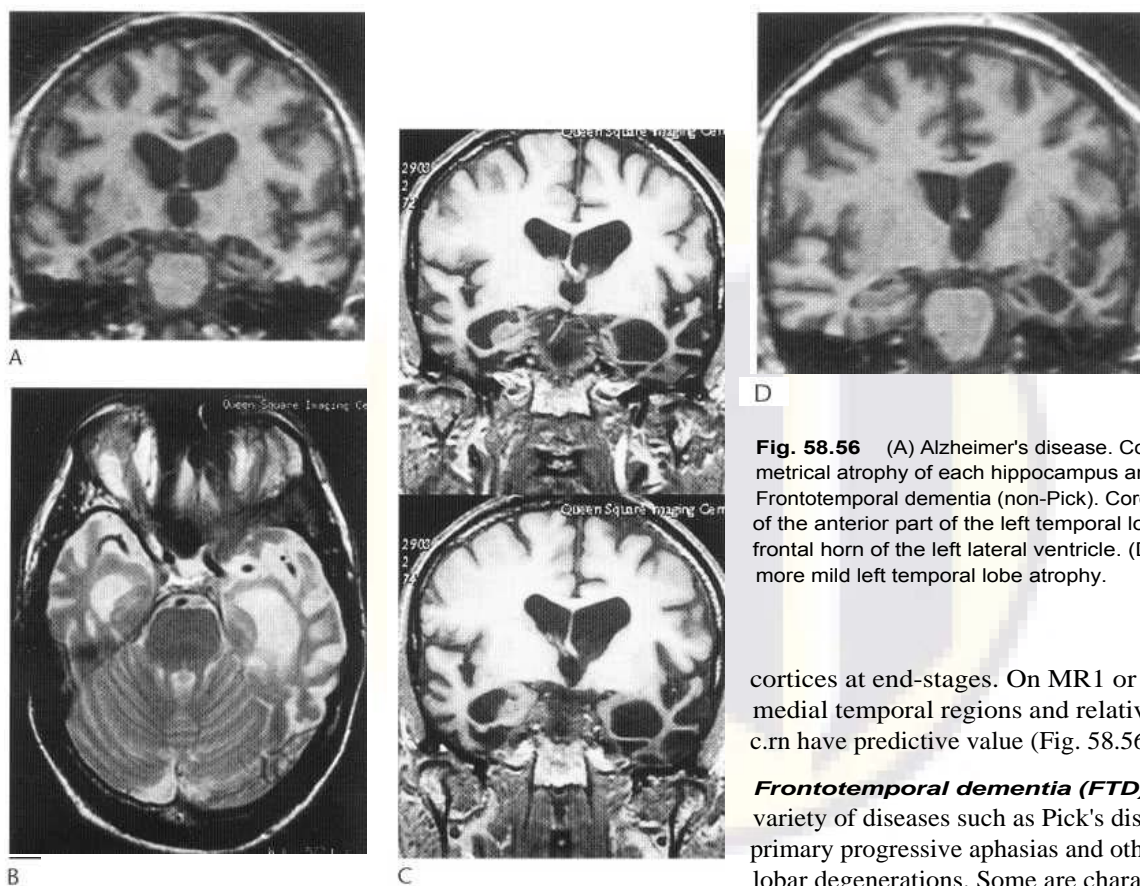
(A) Alzheimer's disease. Coronal MRI showing bilateral symmetrical atrophy of each hippocampus and parahippocampal gyrus. (B,C) Frontotemporal dementia (non-Pick). Coronal MRI showing severe atrophy of the anterior part of the left temporal lobe and mild enlargement of the frontal horn of the left lateral ventricle. (D) True Pick's disease, showing more mild left temporal lobe atrophy.
